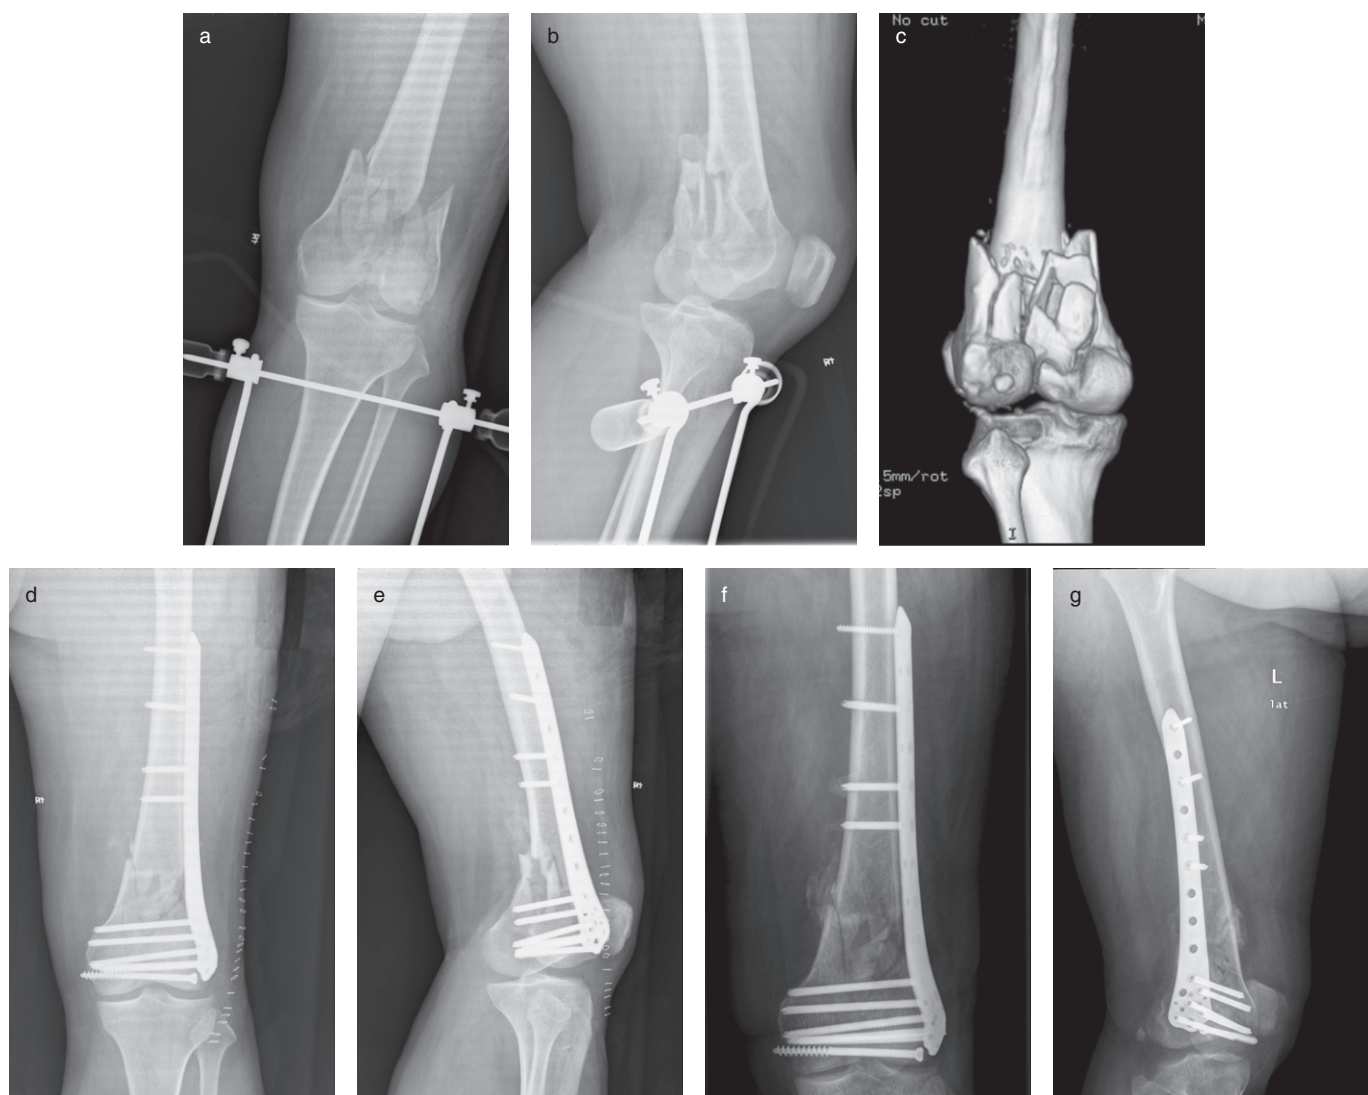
Type 33-C1 fracture in patient with post-polio syndrome. A 50-year-old man had from polio during childhood. Fracture of his distal femur occurred when he slipped and fell at home. (a, b) Anteroposterior and lateral radiographs showing a type 33-C1 fracture. (c) Posterior view of three dimensional construction of the comminuted fracture. (d, e) Postoperative radiographs of distal femur fracture fixed by LCP. (f, g) Radiographs 3 months after surgery showing bone callus on the medial side of the fracture.
